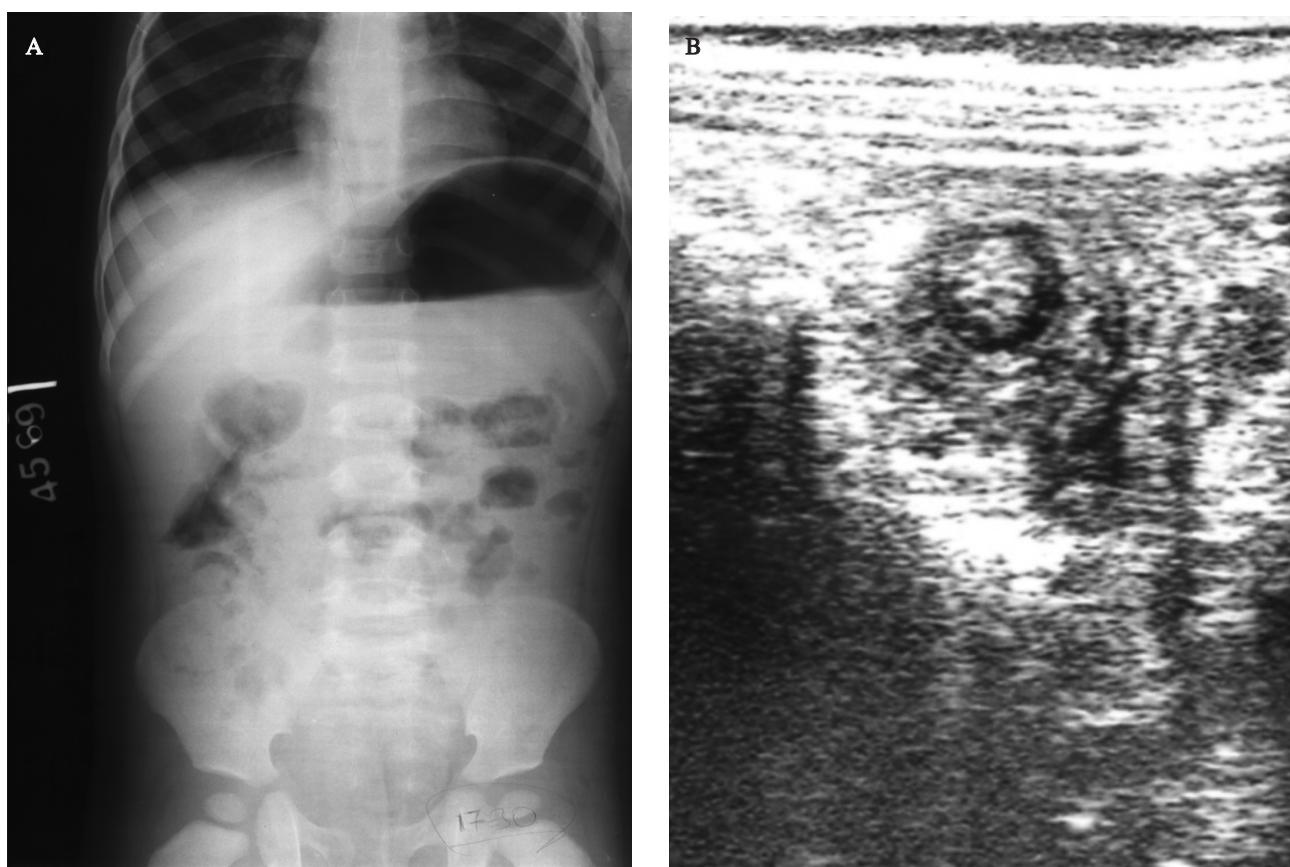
X-ray and ultrasonogram of the abdomen. (A) Abdominal X-ray showing dilated bowel loops and multiple air-fluid levels. (B) The ultrasonogram of the abdomen showing the target sign; the thickened-layered intestine is recognized surrounding the central hyperechoic area, suggestive of intussusception.
